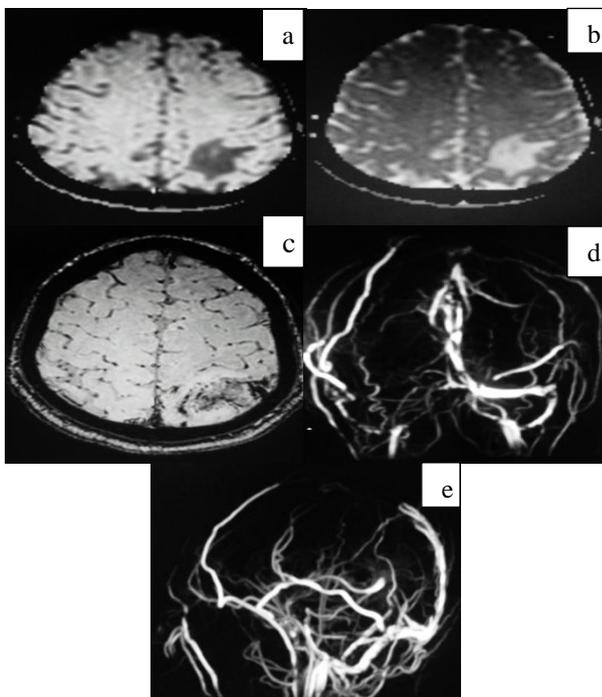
(a) and (b): DWI and ADC images showing infarct in left parietal lobe; (c) SWI showing blooming within the area of infarct and confirms it to be a hemorrhagic infarct; (d) and (e): MRV shows multiple filling defects in superior sagittal sinus, right transverse, sigmoid sinuses and proximal IJV.
